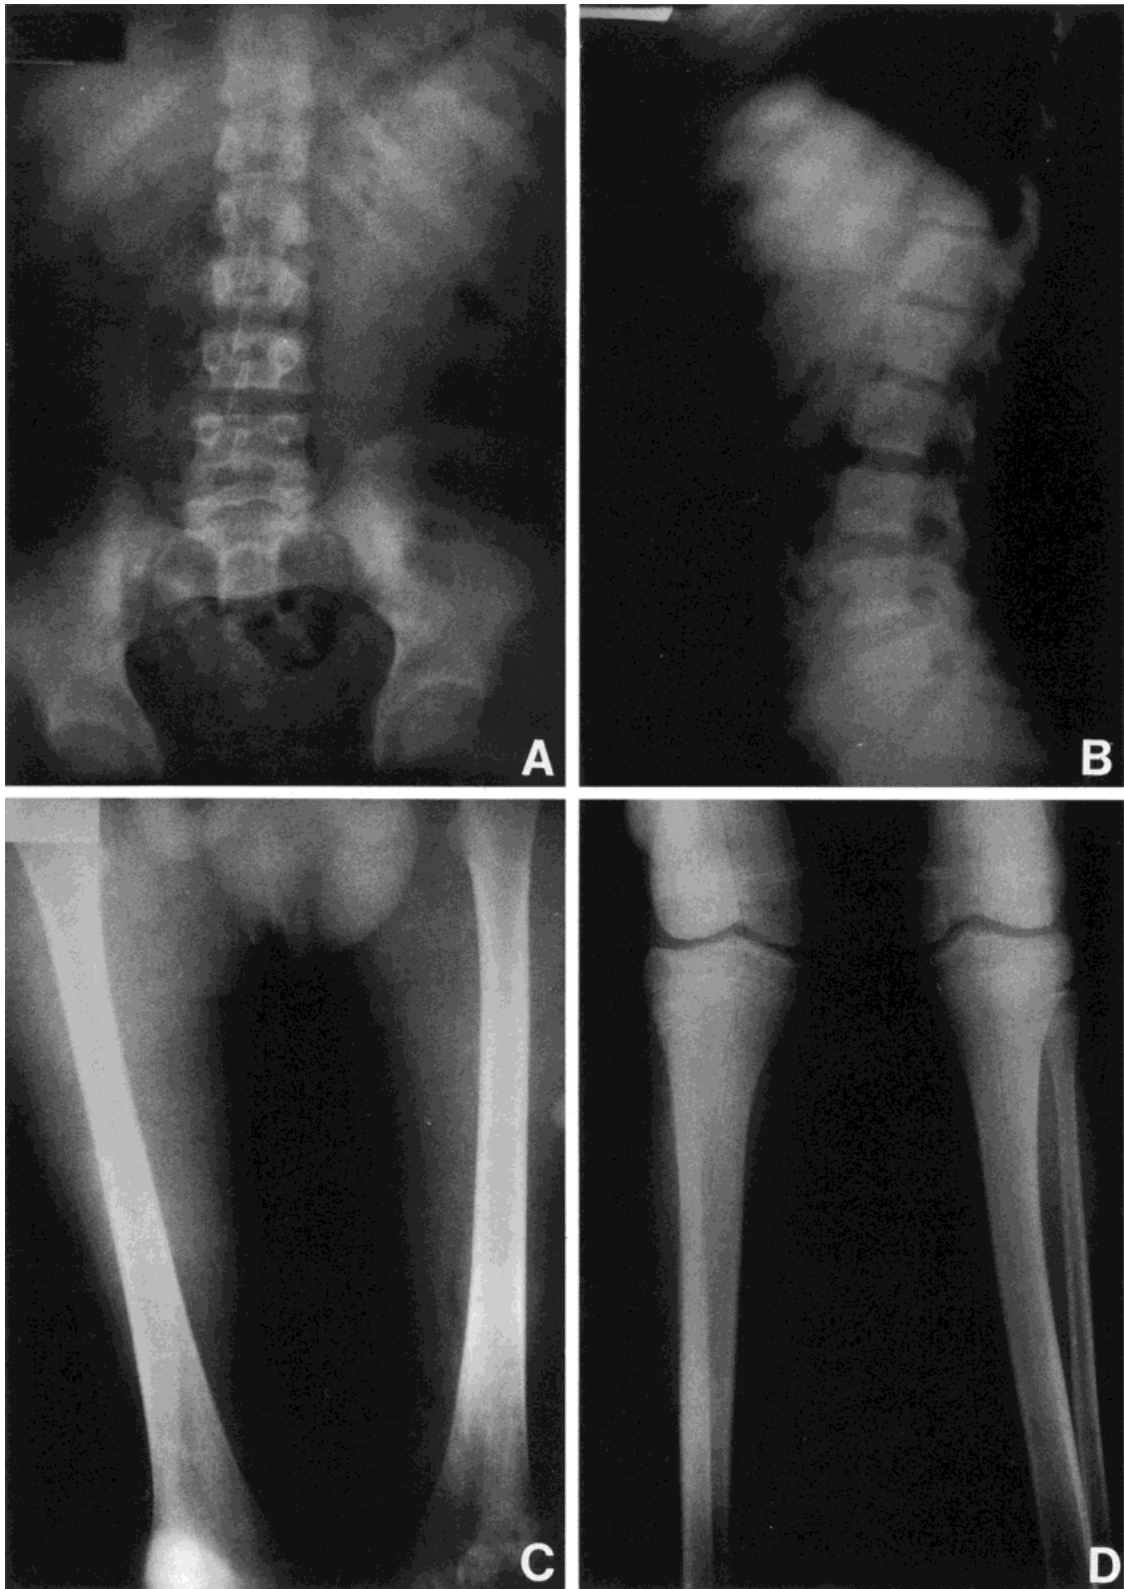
Patient A, X-rays at age, 15 years. Note: (A) Broad ribs; (B) cuboid-shape vertebral bodies with irregular articular surfaces; (C and D) broad metaphyses and medullary canals.
